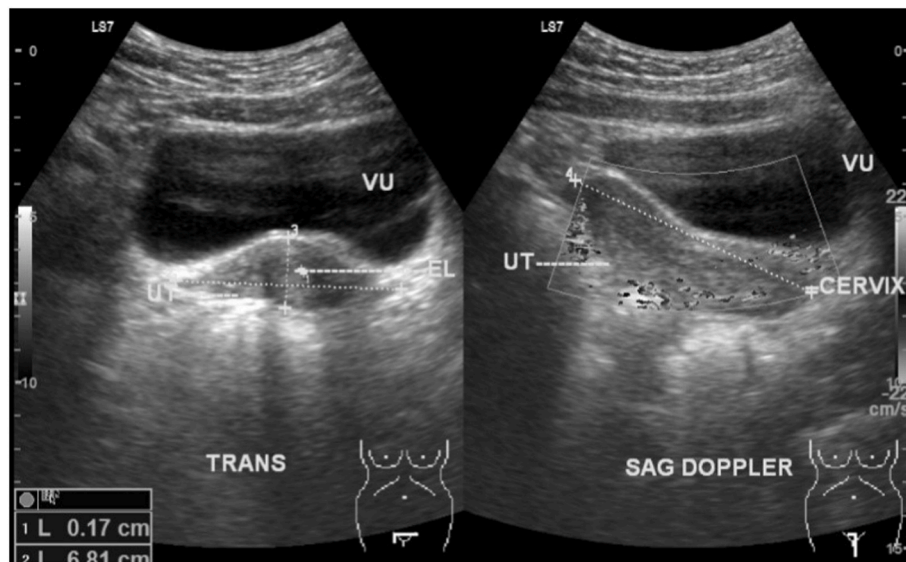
Postoperative abdominal ultrasonography shown uterine in normal condition after the operative being completed.
